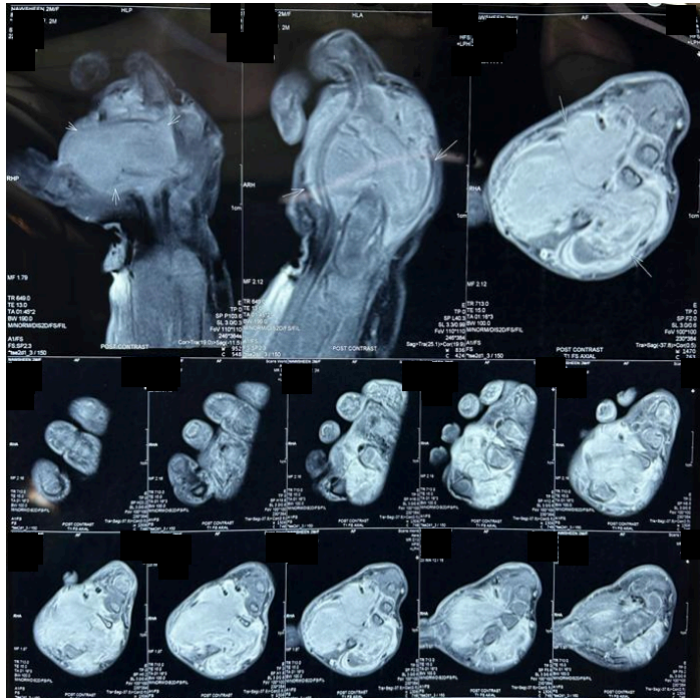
MRI picture of the left hand
